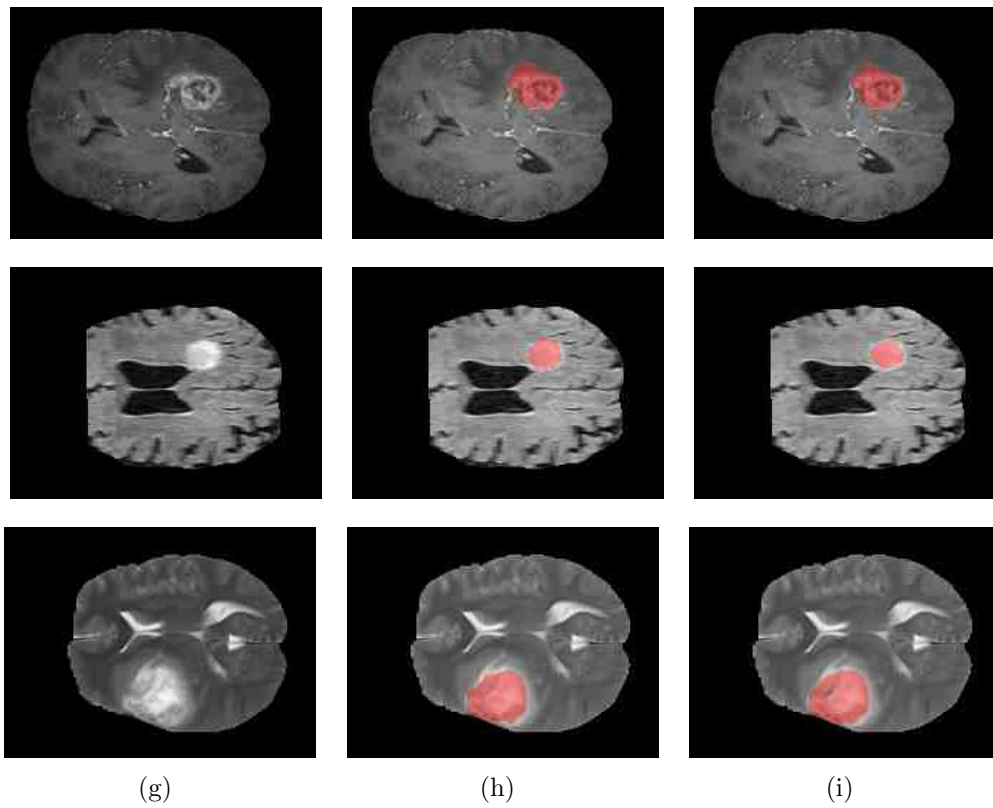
Examples of tumor lesion segmentation on T1-w (first row), FLAIR (second row) and T2-w (third row) real data. (a) original data, (b) golden label, (c) segmented lesion after consistency verification
